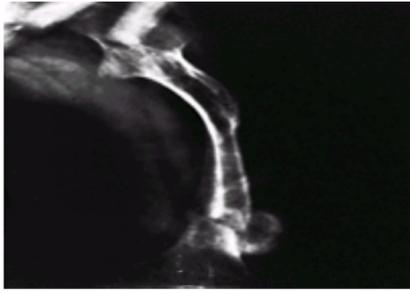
Radiograph of a patient with osteogenesis imperfecta, type I. The patient had blue sclerae. Fractures began soon after birth, with resulting deformity.
